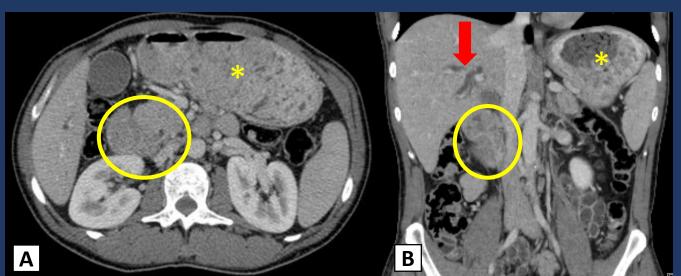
Axial (A) and coronal (B) CT scans showing circunferencial wall thickening of duodenum (circle), in the ampullary region, causing intrahepatic biliary dilatation (arrow) and gastric stasis (asterisk).
